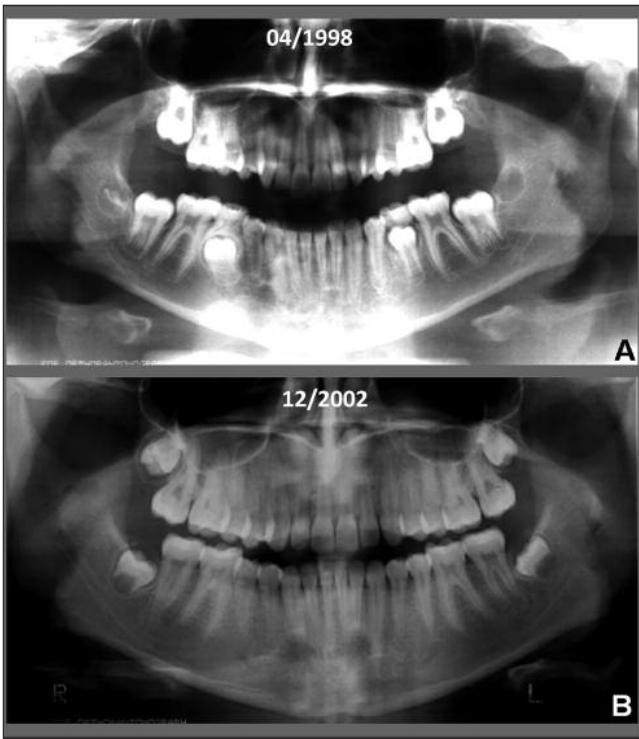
Radiographic evaluation of the difference in rhizolysis between teeth 75 and 85.
